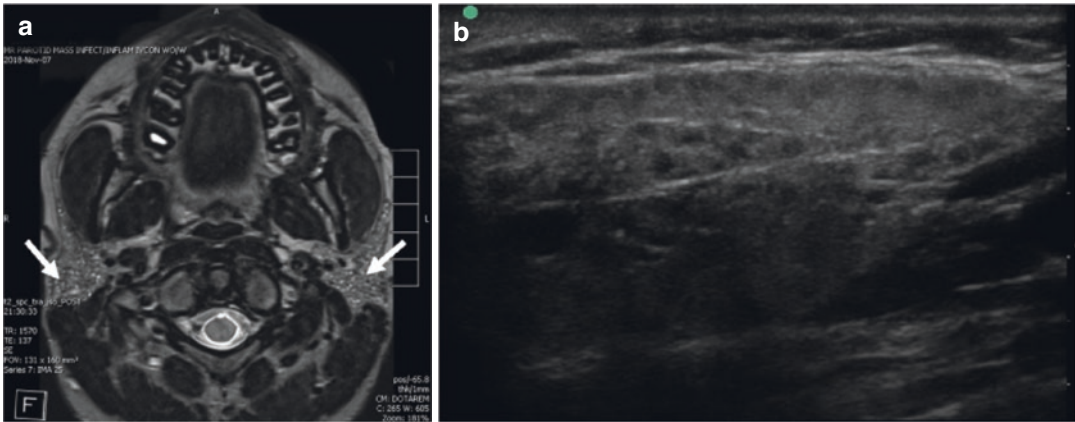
A characteristic MRI finding of the parotid gland of a teenager with juvenile Sjögren's syndrome shows salt-and-pepper appearance (a, white arrow) compared to SGUS (b)
